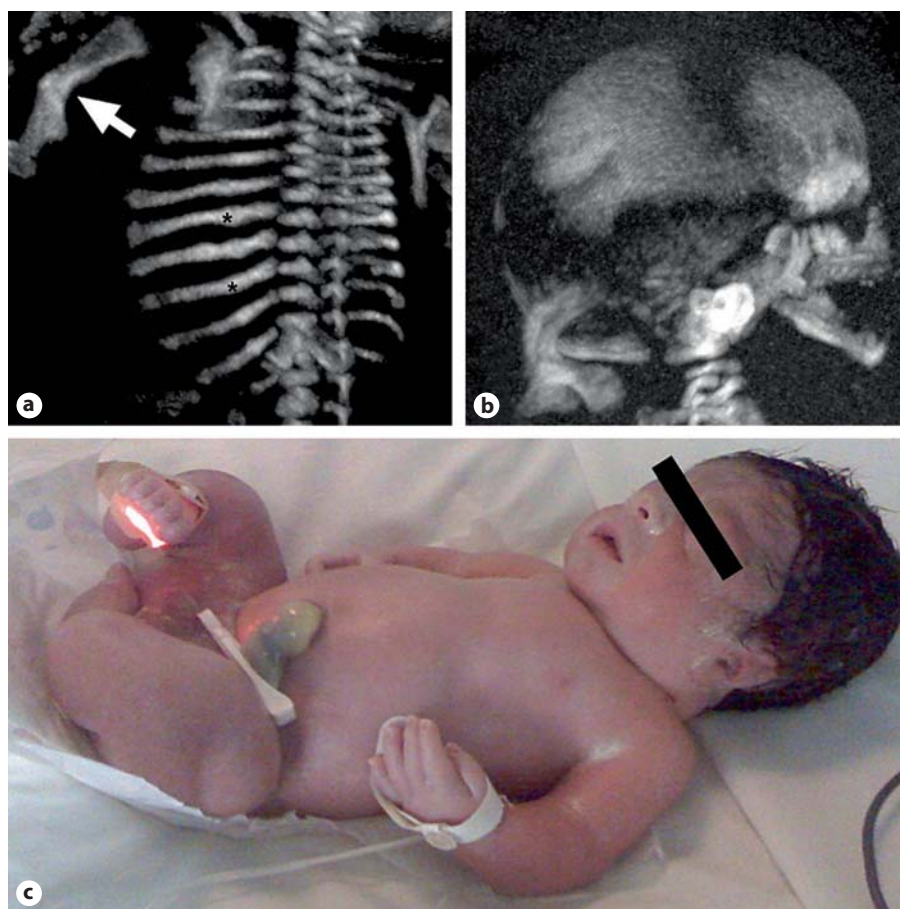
Case 4: osteogenesis imperfecta type II. a 3D-CT MIP reconstruction of the fetal thorax showing 12 pairs of ribs, some of which are fractured (*). Also note bowed upper limb (arrow). b 3D-CT MIP reconstruction with lateral view of the skull showing decreased bone mineralization. c Picture of the newborn.
